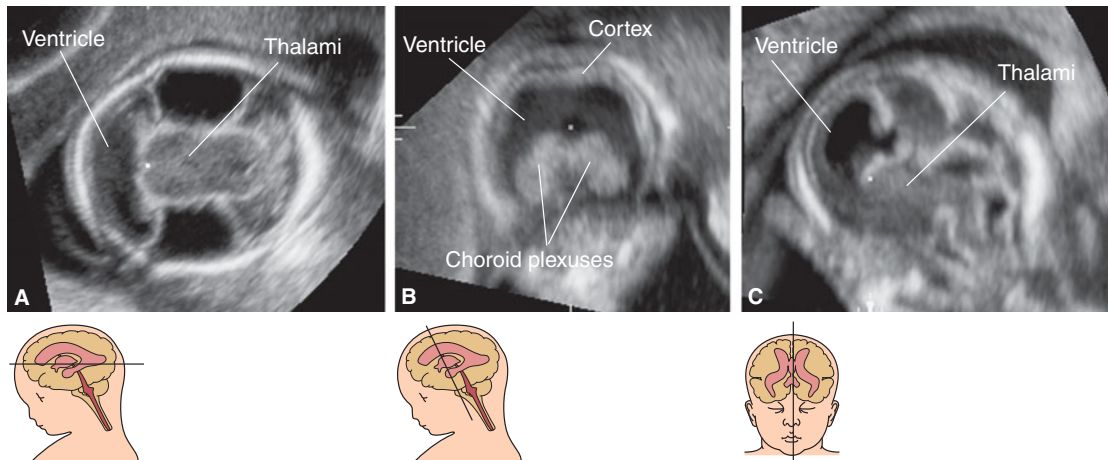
Alobar holoprosencephaly in a fetus at 13 postmenstrual weeks. The most striking findings, the absence of the midline echo and the presence of a single rudimentary ventricular cavity, are well demonstrated in a vaginal scan. (Reproduced, with permission, from Tutschek B, Pilu G. Virtual reality ultrasound imaging of the normal and abnormal fetal central nervous system. *Ultrasound Obstet Gynecol.* 2009;34(3):259–267.)
